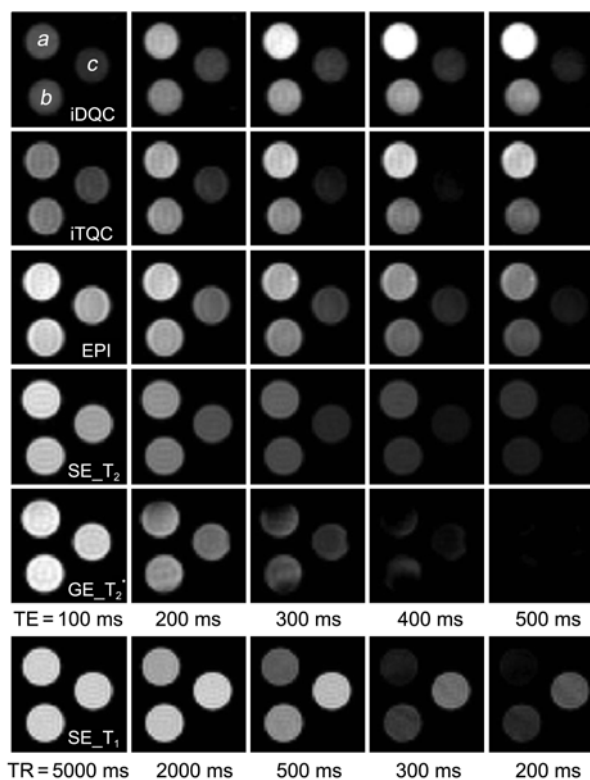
The MR images for the three parts having different CuSO₄ contents (*a*: 0.25 g/L CuSO₄, *b*: 0.50 g/L CuSO₄, and *c*: 1.00 g/L CuSO₄ aqueous solution) acquired with TE (or TR for SE_ T_1) variation.
